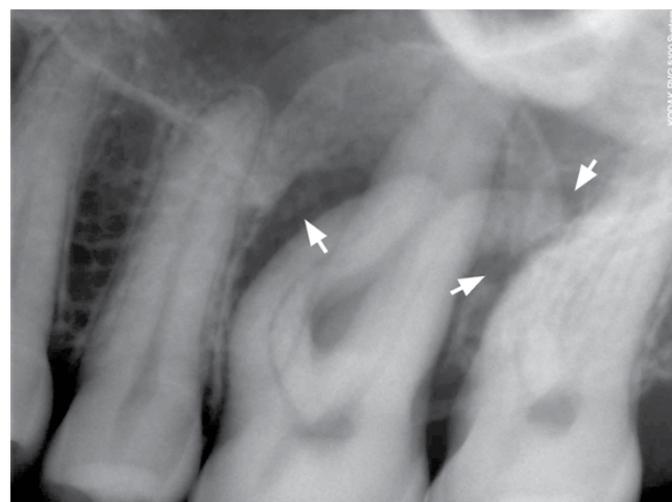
Preoperative intraoral digital periapical radiography showed that the periapical lesion (arrows) created an antral halo.
